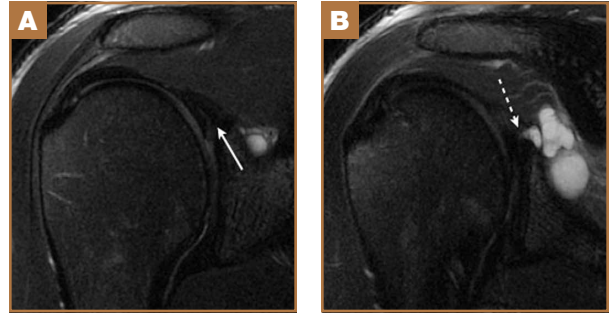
Fat-saturated coronal T2-weighted magnetic resonance imaging of shoulder shows thin, linear focus of signal within chondrolabral junction and substance of labrum (A, solid arrow) with multiloculated, high-signal, paralabral cyst within spinoglenoid notch, which communicates with labral tear (B, dotted arrow). Linear signal of tear is much less conspicuous on conventional imaging than on magnetic resonance arthrography.
